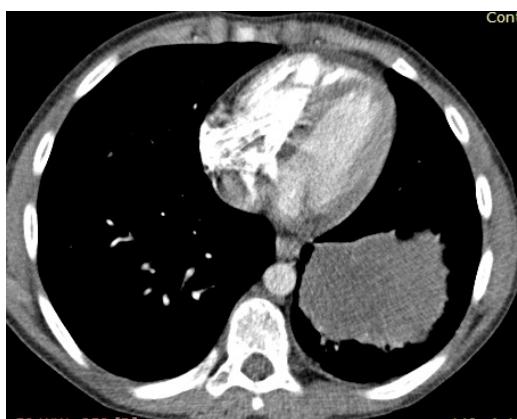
CT chest and abdomen October 2017*
